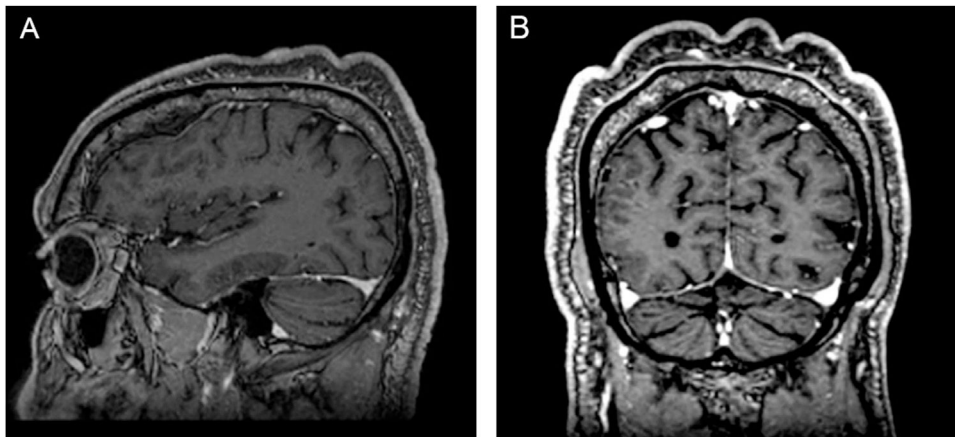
Magnetic resonance imaging of the skull. (A), Sagittal section. (B), Coronal section, showing skin undulations.
